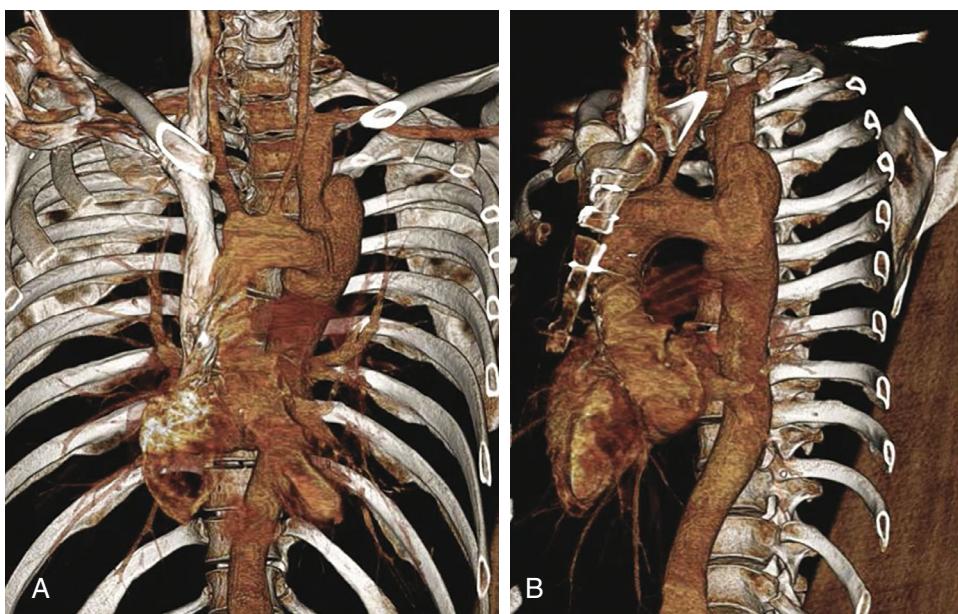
3D reconstruction of computed tomography angiographic imaging of a patient with Loeys-Dietz syndrome and a large left subclavian artery aneurysm in coronal (A) and sagittal projections (B). (Courtesy Dr. Matthew Sweet, Seattle, WA.)
